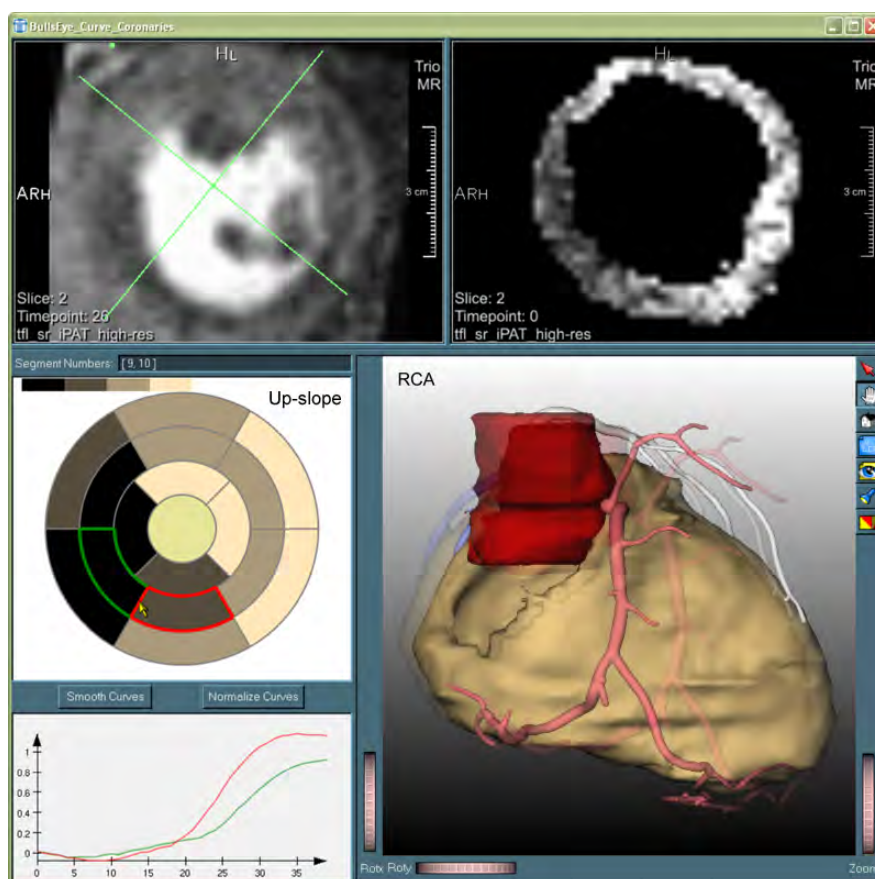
Combined inspection of CT coronary angiography and myocardial perfusion as proposed in Oeltze et al. [2006]. The 2D parameter map and the 3D visualization are automatically chosen such that the region corresponding with the segment selected in the bulls-eye-plot is shown.
